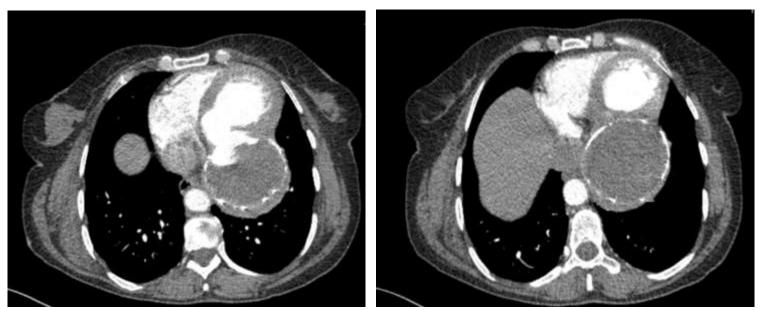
Thoracic CT (after injection of the contrast medium) showing the patient's mass.
